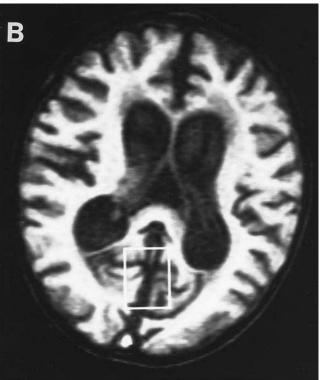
MR images (T<sub>1</sub>-weighted with TE 20 ms, repetition time 600 ms) showing the inferior bounds of the typical location of the regions of interest studied as well as the morphologic changes after ND as detected by MRI. MRI appears normal early after ND (A) but reveals considerable cerebral atrophy 3 mo after ND (B).
